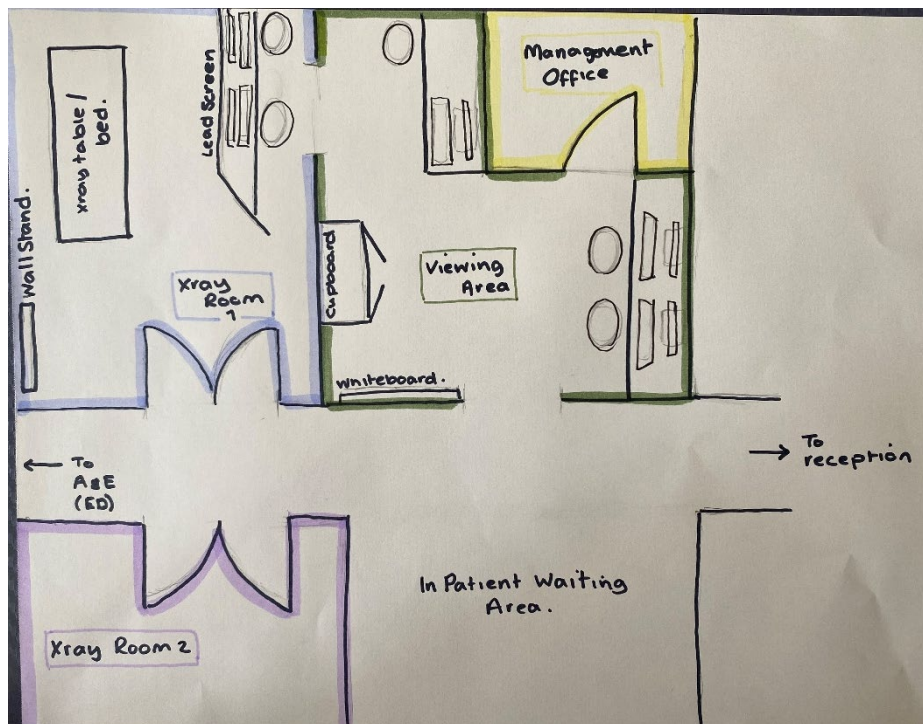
General X-ray department floor plan
